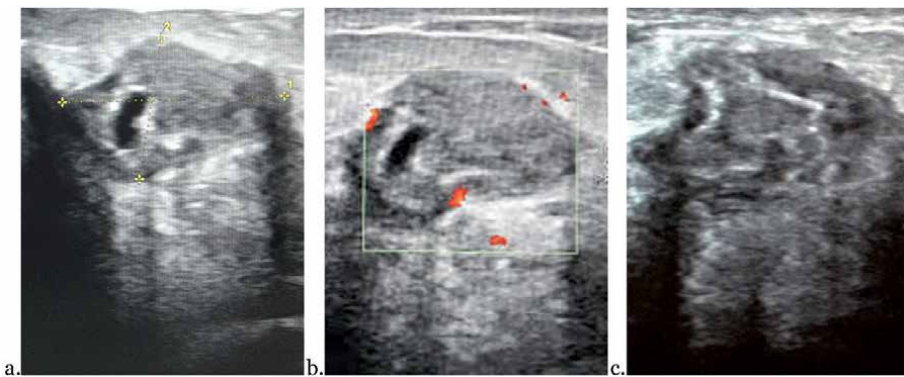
45-year-old female with redness, heat, and pain in the right breast. US: (a) Hypoechoic mass with heterogeneous content, poorly defined borders, and acoustic shadowing. Thickening of the dermal layer. Fat hyperechogenicity around the mass. (b) Image using Doppler signal reveals increased surrounding vascularization. (c) US-Guided Percutaneous Biopsy: Granulomatous Mastitis.
